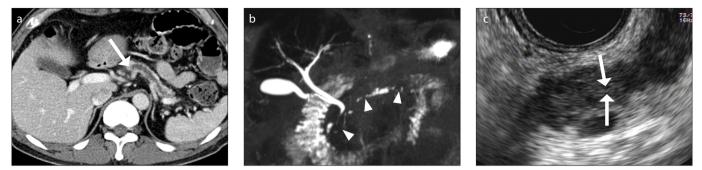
a*–*c*. Case 1, a 47-year-old man with diffuse intraductal tubulopapillary neoplasm (ITPN). Axial contrast-enhanced portal phase CT image (a) shows abrupt cutoff (*arrow*) of the moderately dilated main pancreatic duct in the atrophied pancreas body. Three-dimensional magnetic resonance cholangiopancreatography (MRCP) image (b) shows diffuse irregular dilatation with stricture of the main pancreatic duct (*arrowheads*). From CT and MRCP images, the presumptive radiologic diagnosis was chronic autoimmune pancreatitis. Repeated endoscopic ultrasonography (EUS) image (*c*) reveals a subtle isoechoic solid tumor (*arrows*) within the dilated main pancreatic duct. Positron emission tomography-CT (PET-CT) showed mild ¹⁸F-FDG uptake suggesting a benign inflammatory lesion rather than malignancy in the corresponding area (not seen).
